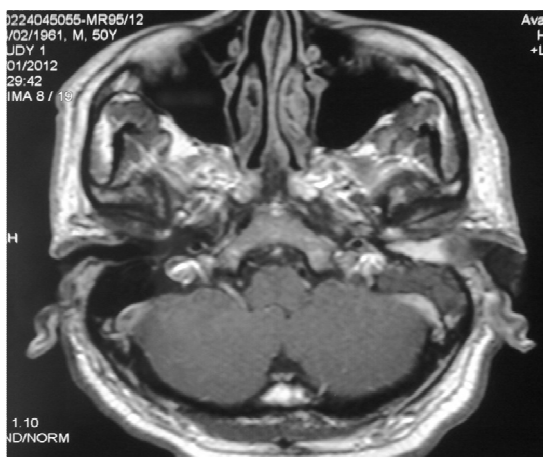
Axial view of contrasted MRI revealing nature and extent of the lesion in the left external and middle ear.
